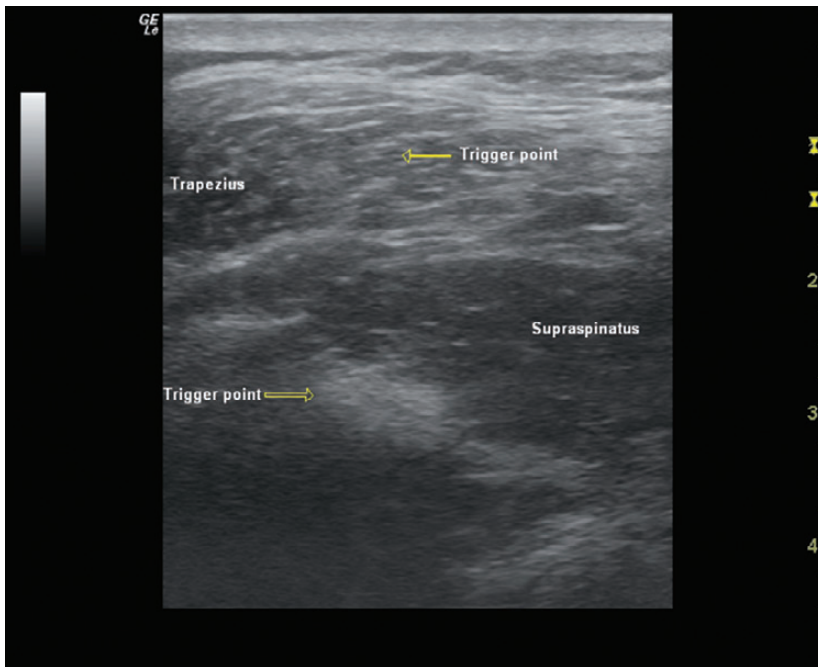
Ultrasound image over a taut band showing the trapezius and supraspinatus muscles with areas of hyperechogenicity corresponding to the taut bands.
